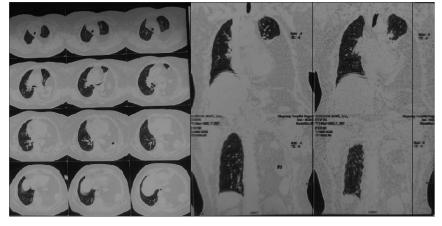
CT Scan showing herniation of colonic loops in left hemi thorax
